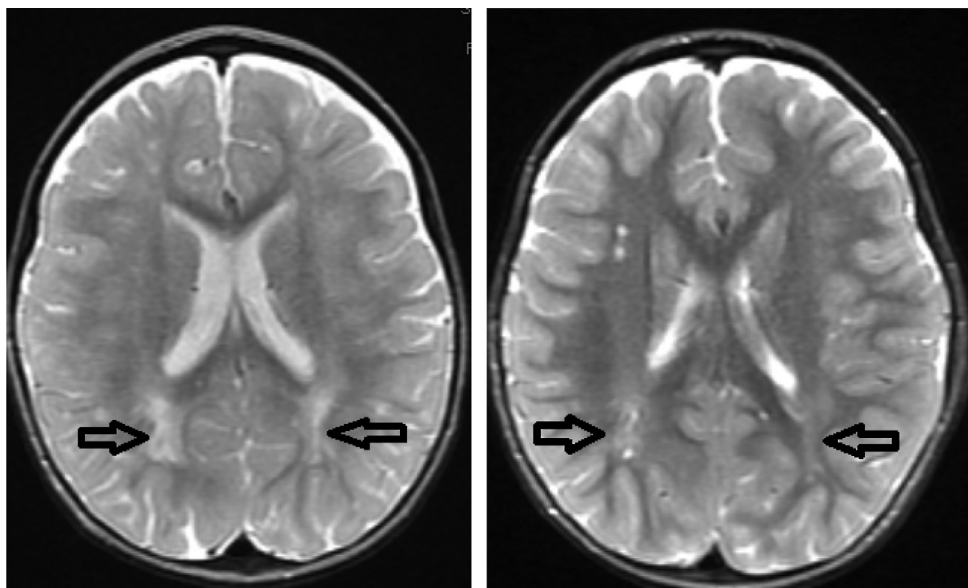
Longitudinal brain MRI. The patient was 2 years of age at first MRI and 4,5 years of age at the second MRI. The arrows indicate a delay in myelination in the occipital region. Also note the presence of enlarged VR spaces in the white matter in the second MRI (not present in the first MRI).
